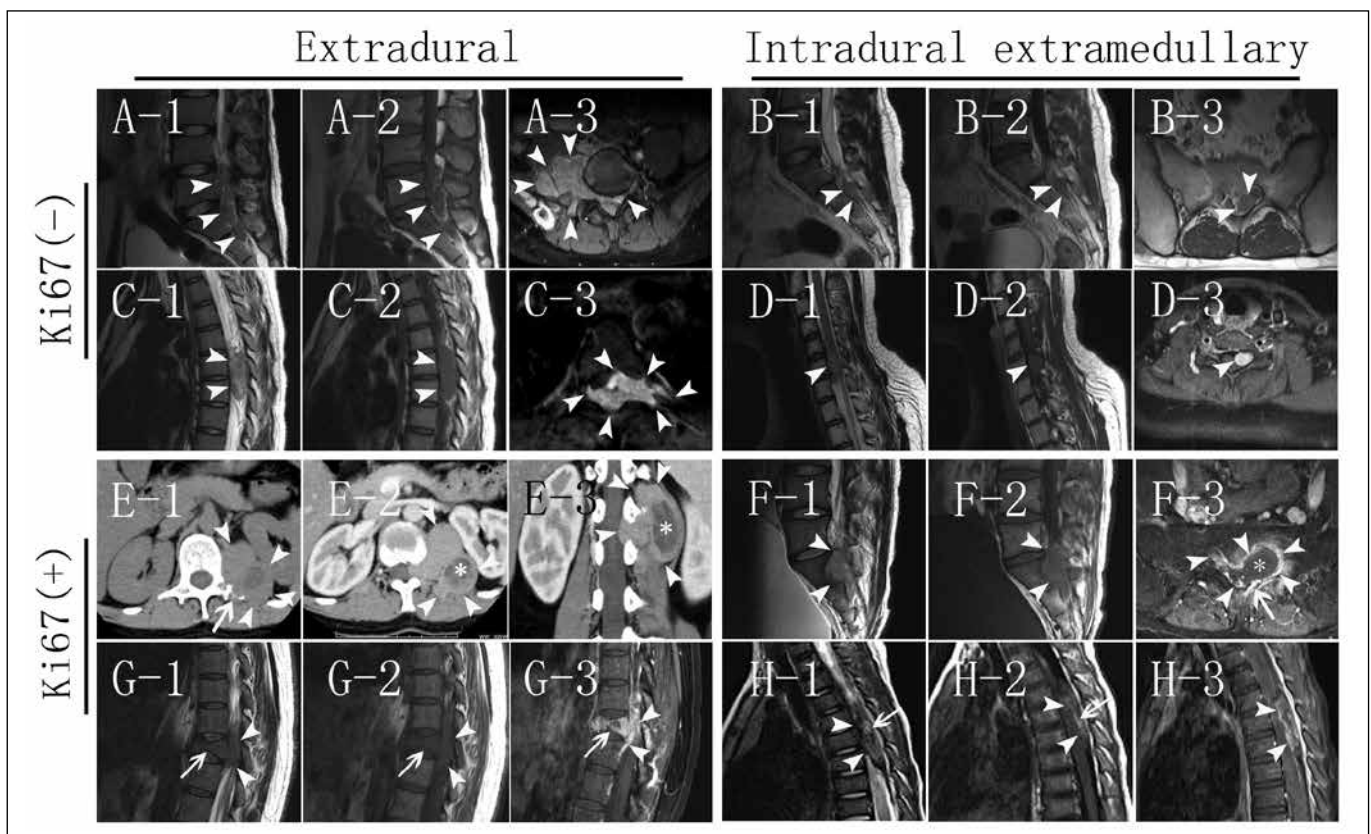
Significant differences of extradural and intradural extramedullary spPNET. (A. Case 3; C. Case 1; E. Case 4; G. Case 6) Images of four extradural masses (CT of one patient and MRIs of three patients)(arrowheads). Three masses (A, C, E) were relatively large, and two masses (A, E) formed an asymmetrical paraspinous soft tissue mass. Three masses (A, C, G) exhibited a “vault wall-like growth” pattern (arrowheads). Two masses (E, G) showed bone destruction (arrow). (B. Case 2; D. Case 5; F. Case 9; H. Case 10) MRIs of four patients with intradural extramedullary masses (arrowheads). Three masses (B, D, F) were relatively small. No asymmetrical paraspinous soft tissue mass formation was observed, and none exhibited a “vault wall-like growth” pattern, except for the mass shown in F. Five masses showed an obvious “drilling hole” pattern (A, C, D, E, F).
